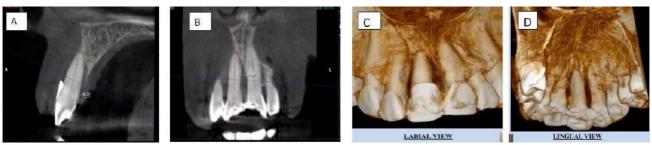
Pre operative CBCT :A) 10.77mm bone loss sagittally B) 10.97mm bone loss coronally C) Labial view D) Lingual view
